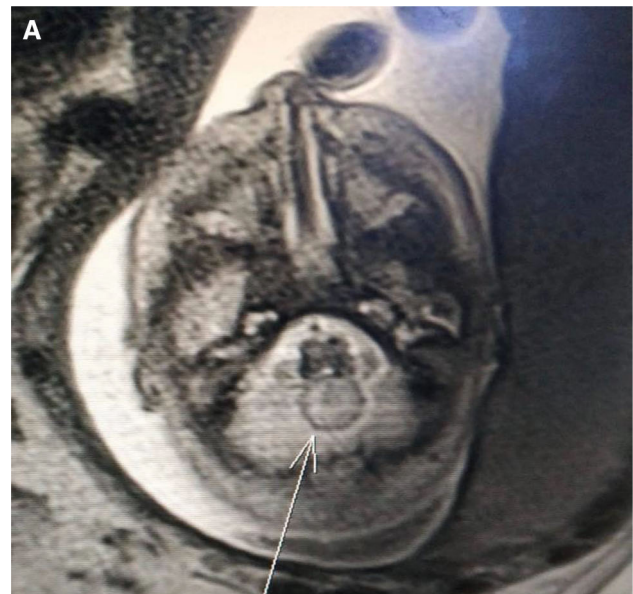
Fetal magnetic resonance imaging at 22 weeks showing a solid mass (arrow) in the infratentorial subarachnoid spaces on T2 weighted axial (A) and sagittal (B) images with a signal similar to normal brain tissue
